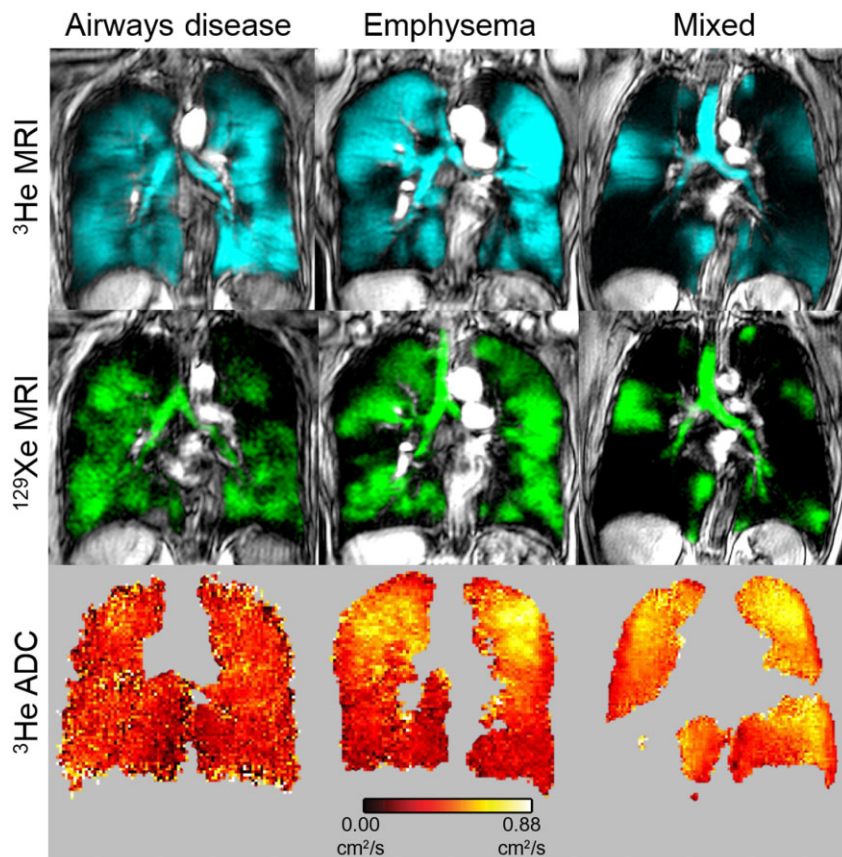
Hyperpolarized noble gas MR images. ^3He and ^{129}Xe static ventilation and ^3He ADC images shown below. From left to right: airways disease dominant, emphysema dominant and mixed phenotype. Airways disease dominant: VDP = 8%, ADC = 0.32 cm^2/s ; Emphysema dominant: VDP = 12%, ADC = 0.40 cm^2/s ; Mixed: VDP = 45%, ADC = 0.42 cm^2/s .
